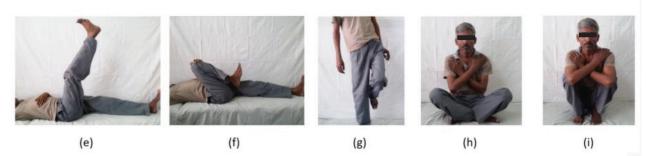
a: Radiograph of right hip showing AO31A2.3 fracture.
